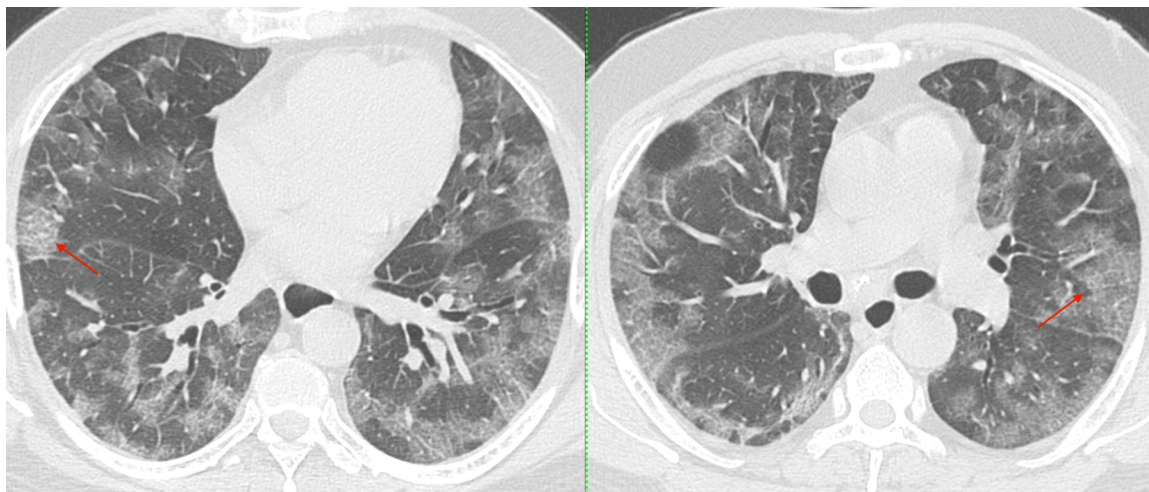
HRCT of the lungs shows a characteristic pattern of subpleural ground glass and septal thickening, giving rise to a “crazy-paving” pattern.
